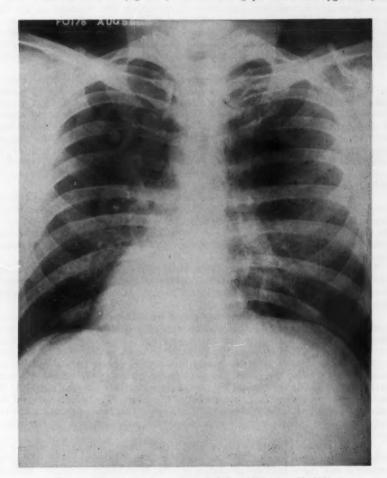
Normal chest x-ray on admission, November 22, 1954.
